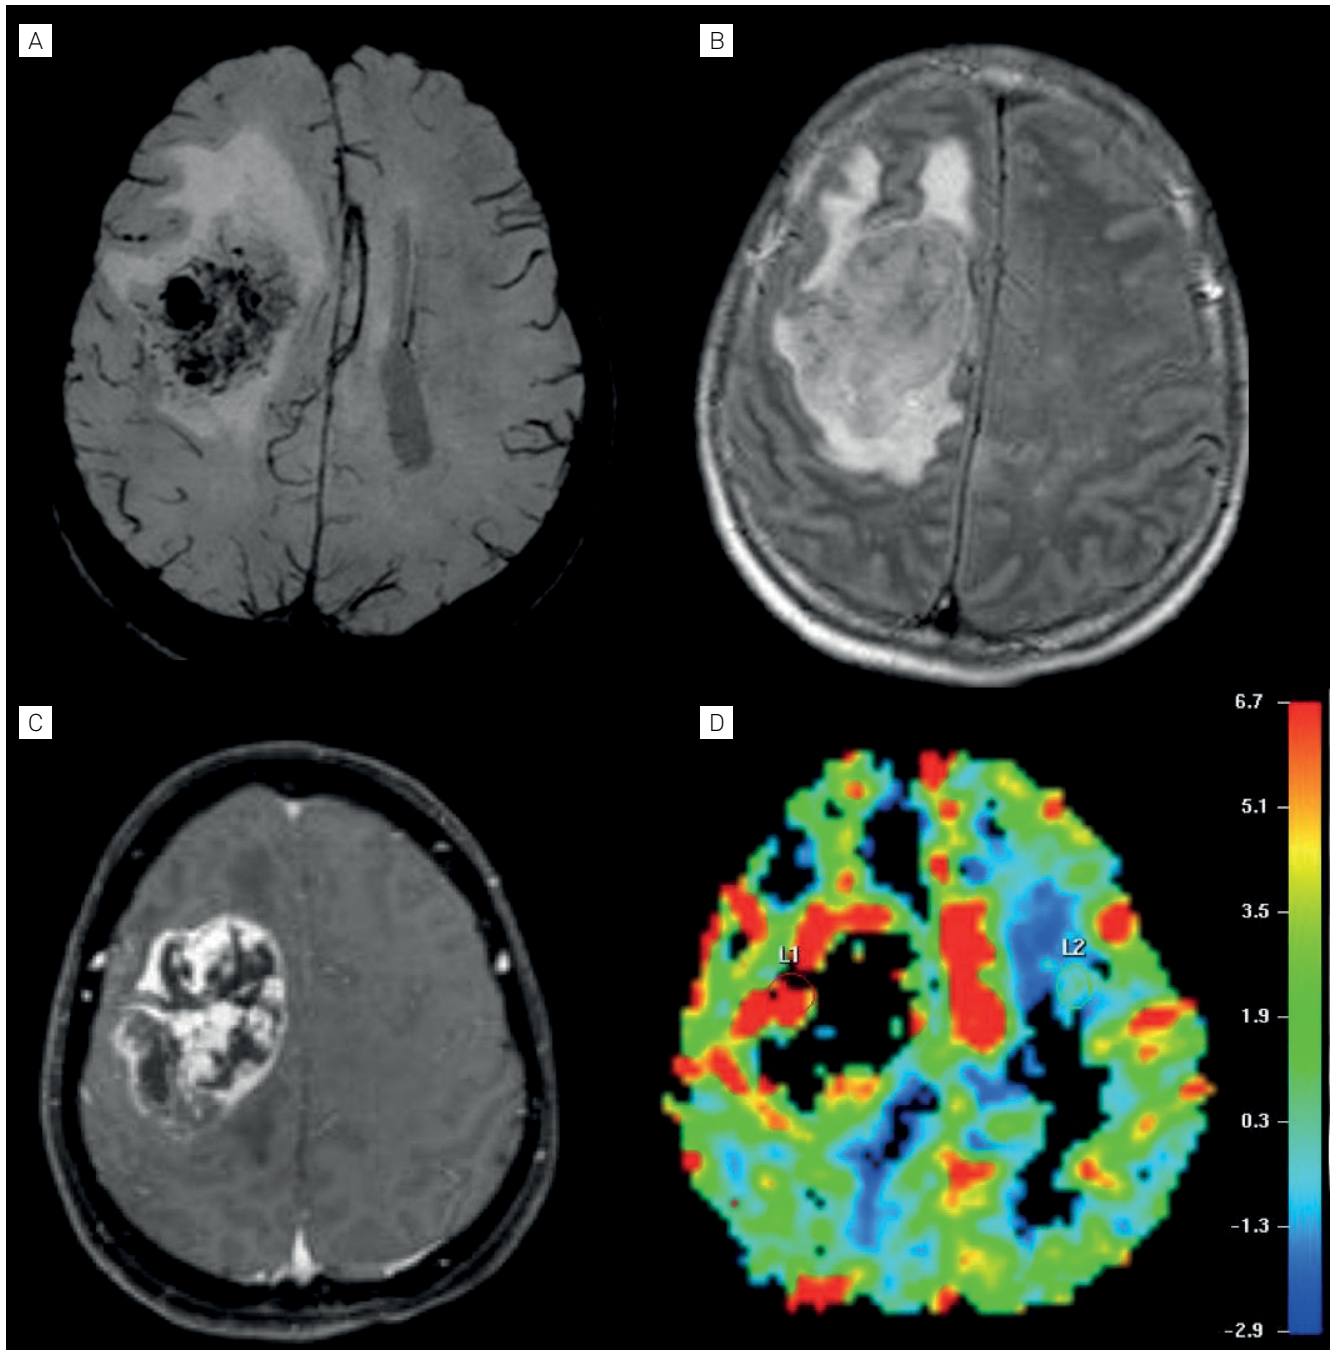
A 63-year-old female patient with a focal convulsive crisis on the left who evolved with left hemiparesis over a two-month period. (A) Axial image in SWI showing intralesional low-signal multifocal zones consistent with neovascularization/flow voids. (B) Axial image FLAIR showing an isointense lesion with peritumoral edema. (C) Axial image T1-weighted after the administration of gadolinium. Note the irregular contrast enhancement. (D) Perfusion map showing increased relative cerebral blood volume (rCBV) in the tumor.
